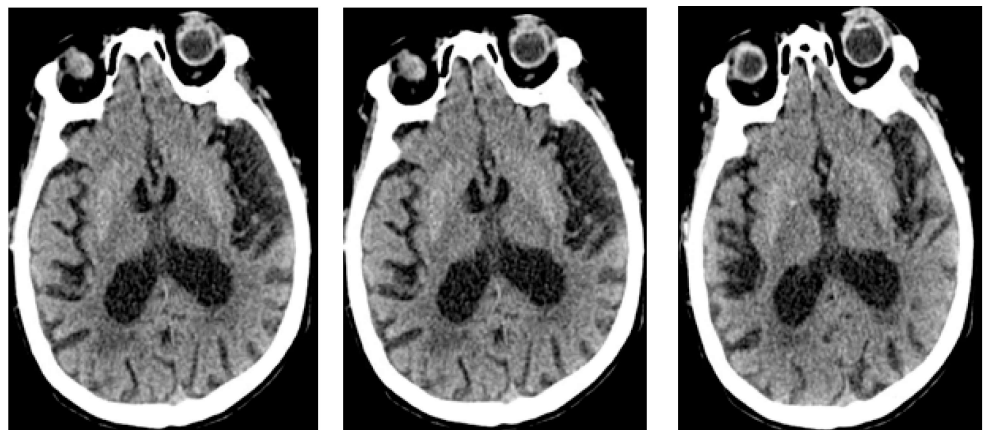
CT Head w/o contrast, axial view
